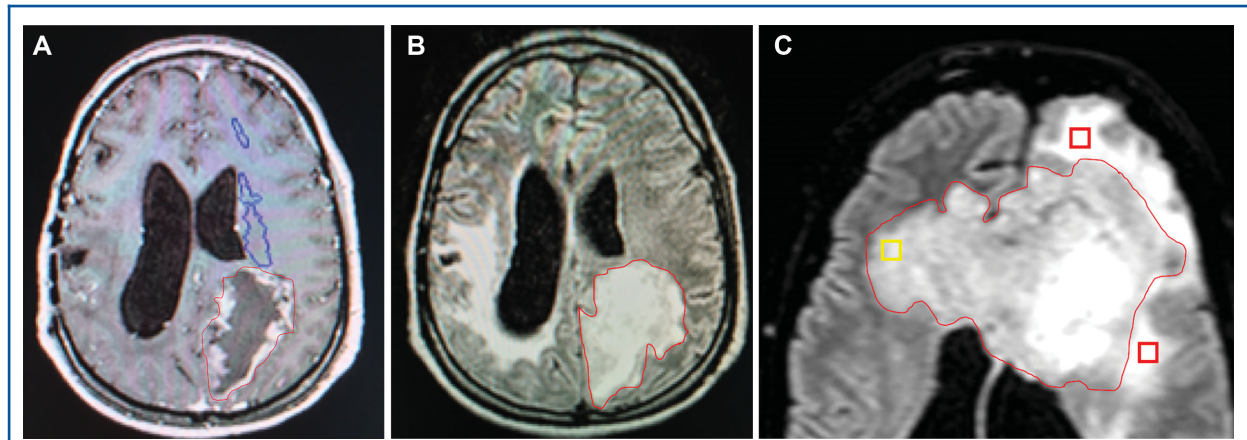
Manual segmentation based on T1-Gad A and FLAIR B sequences for volumetric evaluation of HGG. The segmented pathological area on FLAIR sequences was selected according to the hyperintensity value recorded by multiple ROIs placed in different peritumoral areas, in each slice used for segmentation C. In this case the yellow ROI revealed a lower hyperintensity value than 2 red ROIs peripherally placed. This differentiates tumor (yellow ROI), included in segmented areas, from edema (red ROIs) excluded from the segmented lesion.
